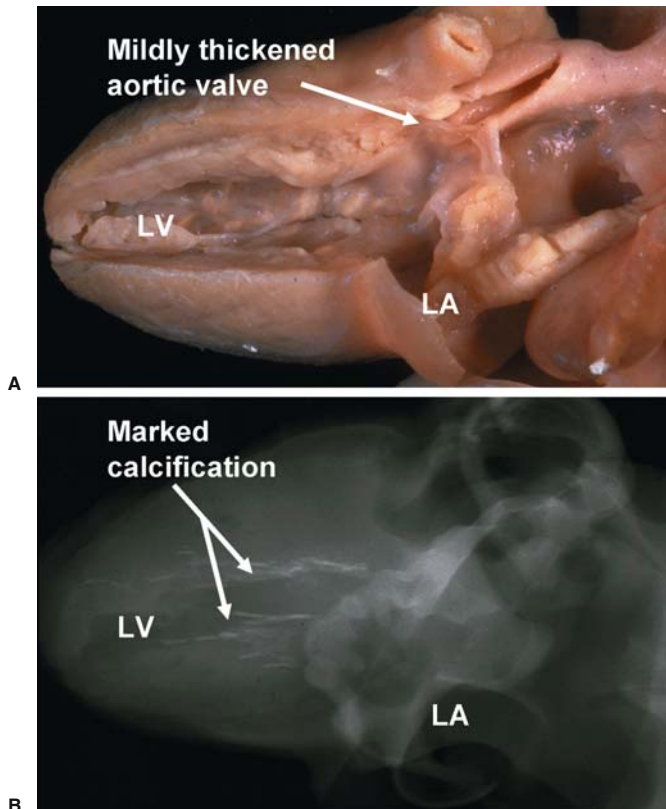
An example of a fetus with aortic valvular stenosis showing that left ventricular changes are often more severe than those in the aortic valve, suggesting that the primary abnormality is of the left ventricle. In this fetus, the aortic valve is only mildly thickened and there is minimal endocardial fibroelastosis (EFE) present (A), but a microfocal x-ray shows marked calcification of the left side of the ventricular septum and papillary muscles (B). LV, left ventricle; LA, left atrium.
